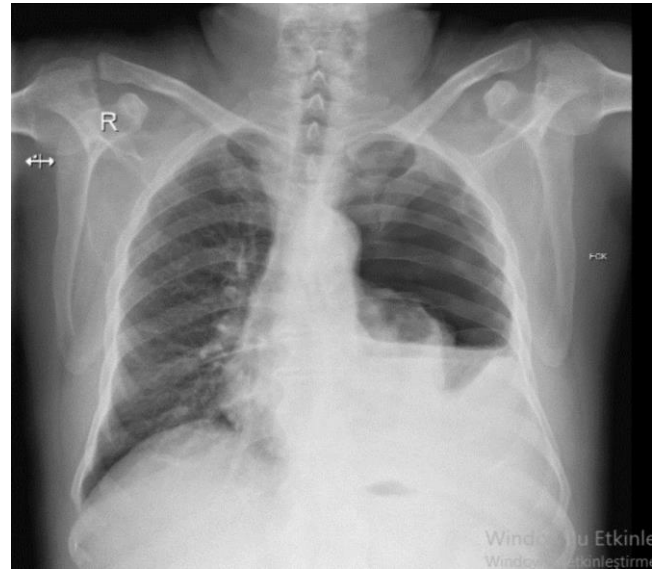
Preoperative left hydropneumothorax seen on chest X-ray
